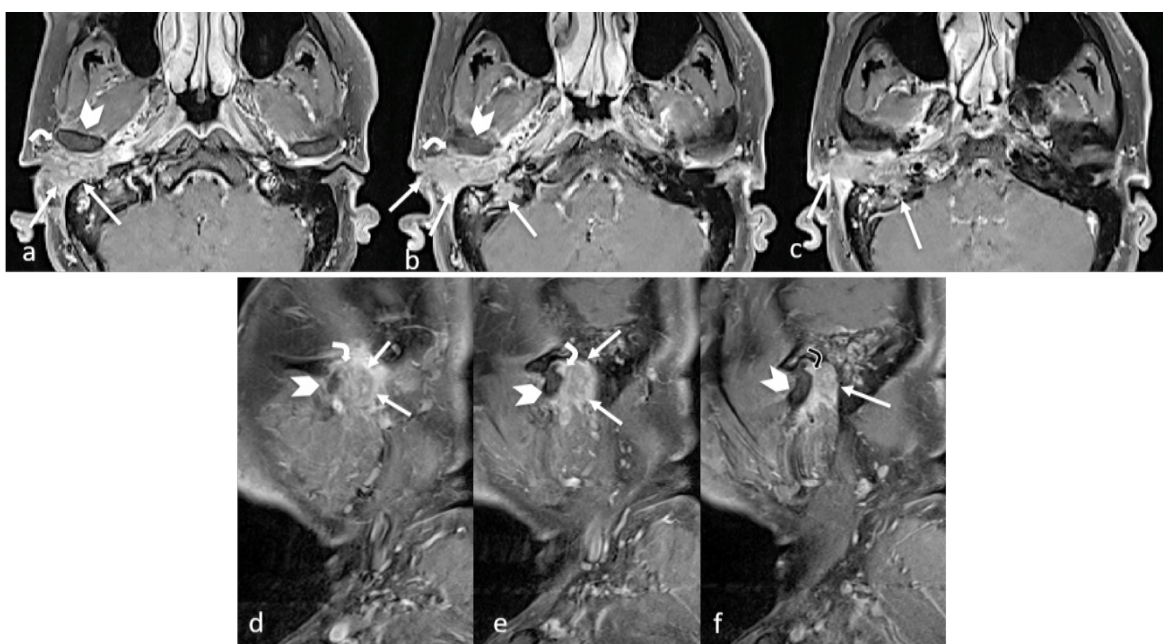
MRI T1 fat saturation post contrast in axial from inferior to superior (a, b, c) and in sagittal from lateral to medial (d, e, f). The mass occupies the external auditory canal extending to the middle ear cavity (white arrow). Anteriorly, extension into the right Temporomandibular Joint (TMJ) is suspected (curve black arrow). The tumor extension is limited only to the lateral part of the TMJ as medially the tumor margin is clearly seen to be separated from the TMJ (curve black arrow in (f)). The mandibular condyle shows normal enhancement without any cortical break suggesting non-involvement of the condyle (arrowhead).
